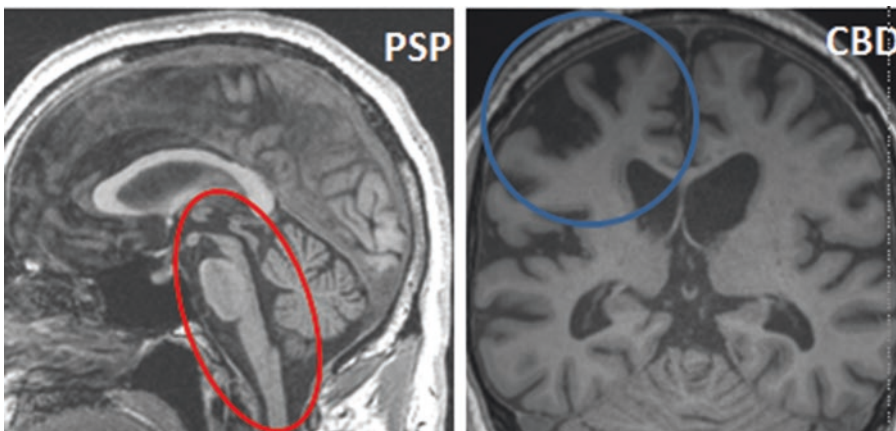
MRI scan in autopsy-confirmed PSP and CBD. MRI scan in PSP shows the classic hummingbird sign on sagittal MRI, while asymmetric atrophy of the posterior frontal cortex is seen in CBD
